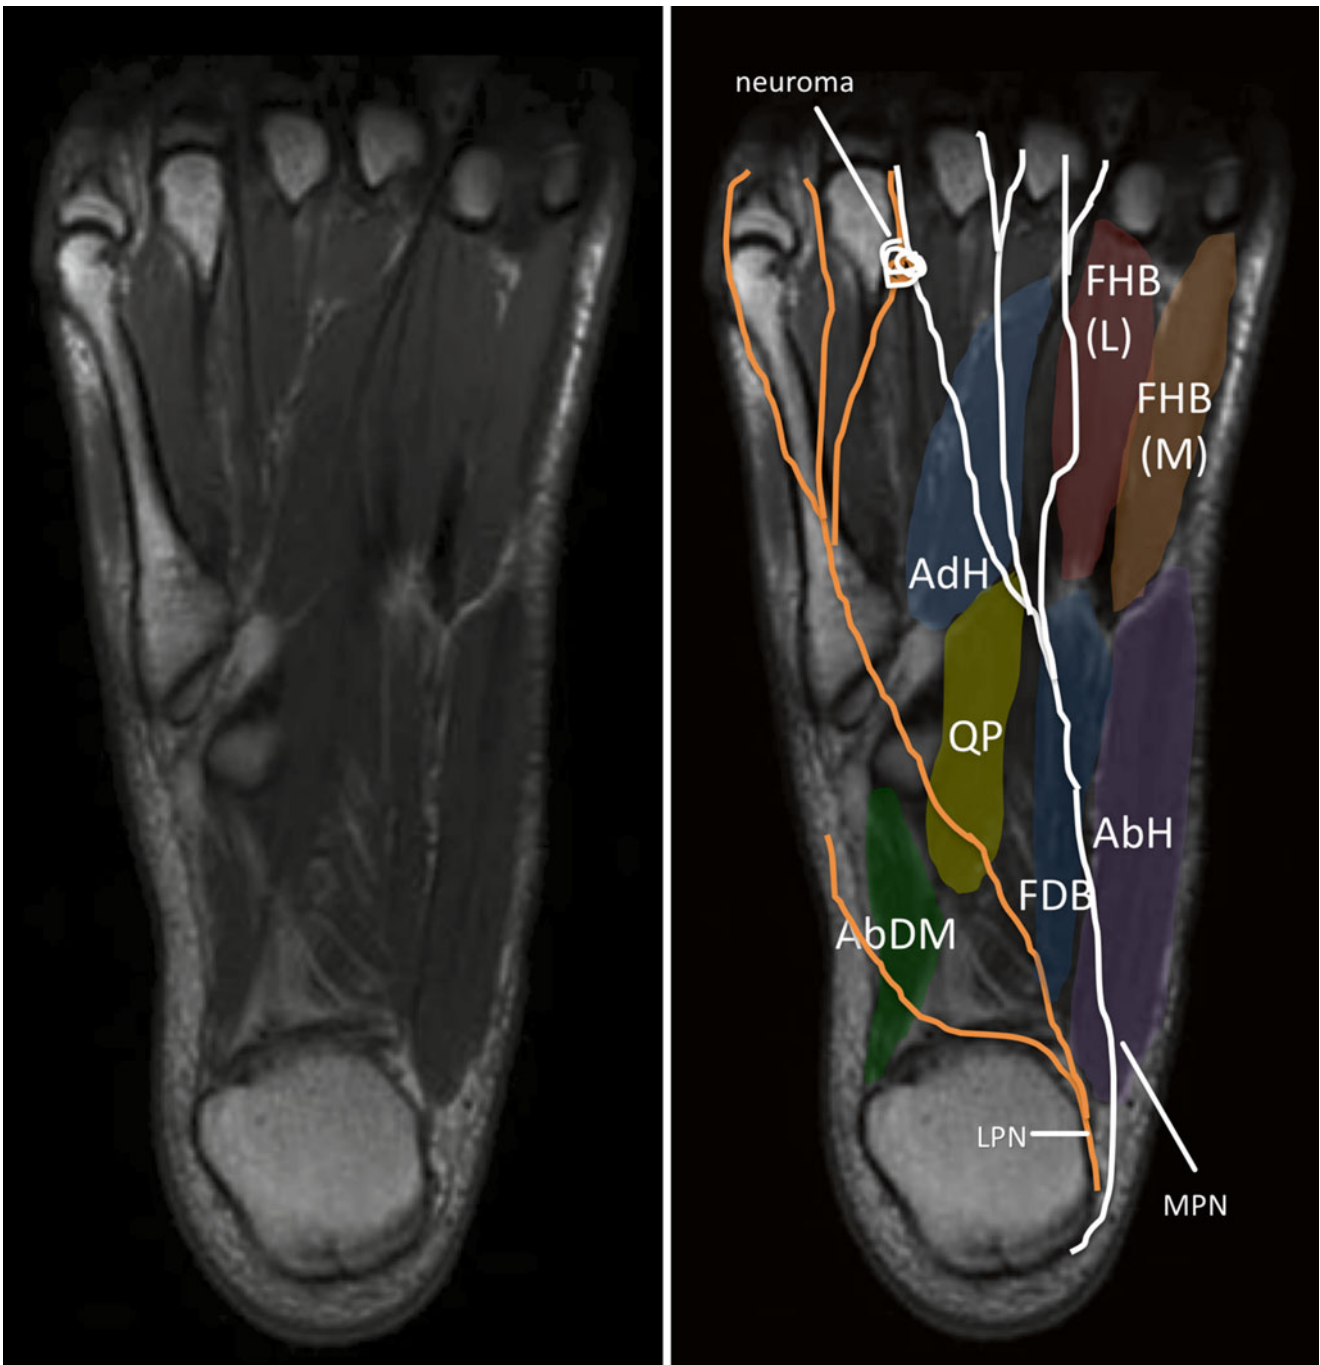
MRI axial image showing foot muscles and nerves. *AdH* adductor hallucis muscle, *AbDM* abductor digiti minimi muscle, *AbH* abductor hallucis muscle, *FDB* flexor digitorum brevis muscle, *FHB*
